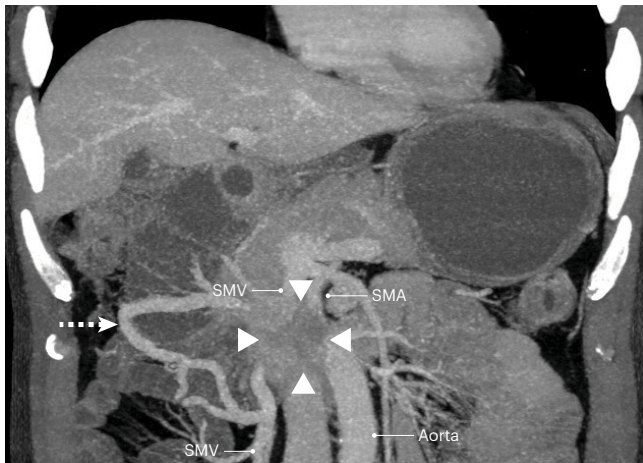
Diagnostic imaging of pancreatic cancer. Coronal maximum intensity projection (portal venous phase CT) image demonstrates a hypodense pancreatic lesion (arrowheads) and displays the relevant blood vessels vividly showing occlusion of the superior mesenteric vein (SMV) with venous collateral (broken arrow) and $\leq 180^\circ$ tumour contact with the superior mesenteric artery (SMA).
